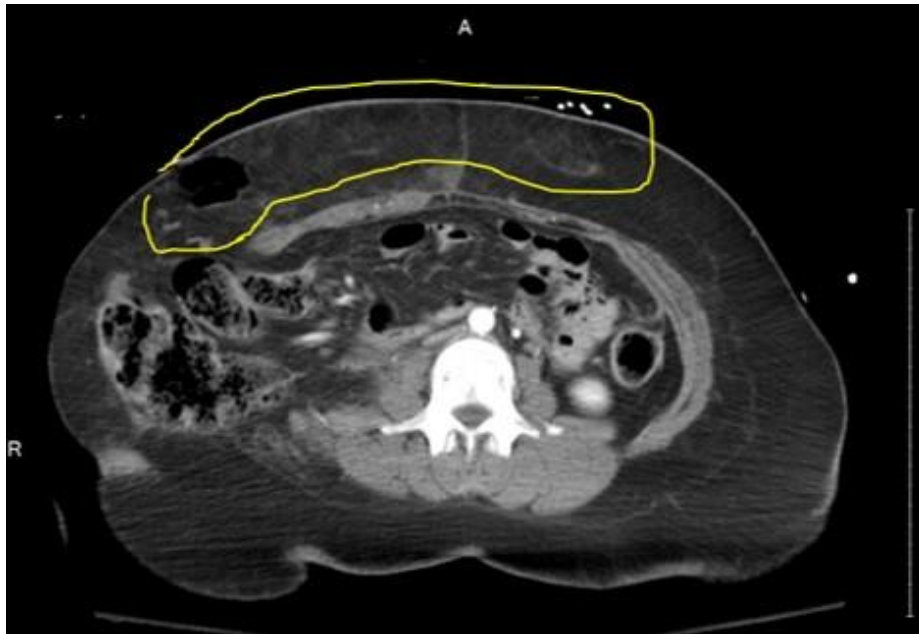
Axial CT at the level of L2-L3 with prominent fat stranding abdominal injuries.
